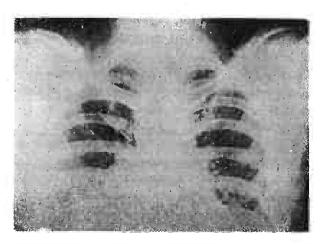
X-ray Chest. Note the large circular opacity in the right hilum.
